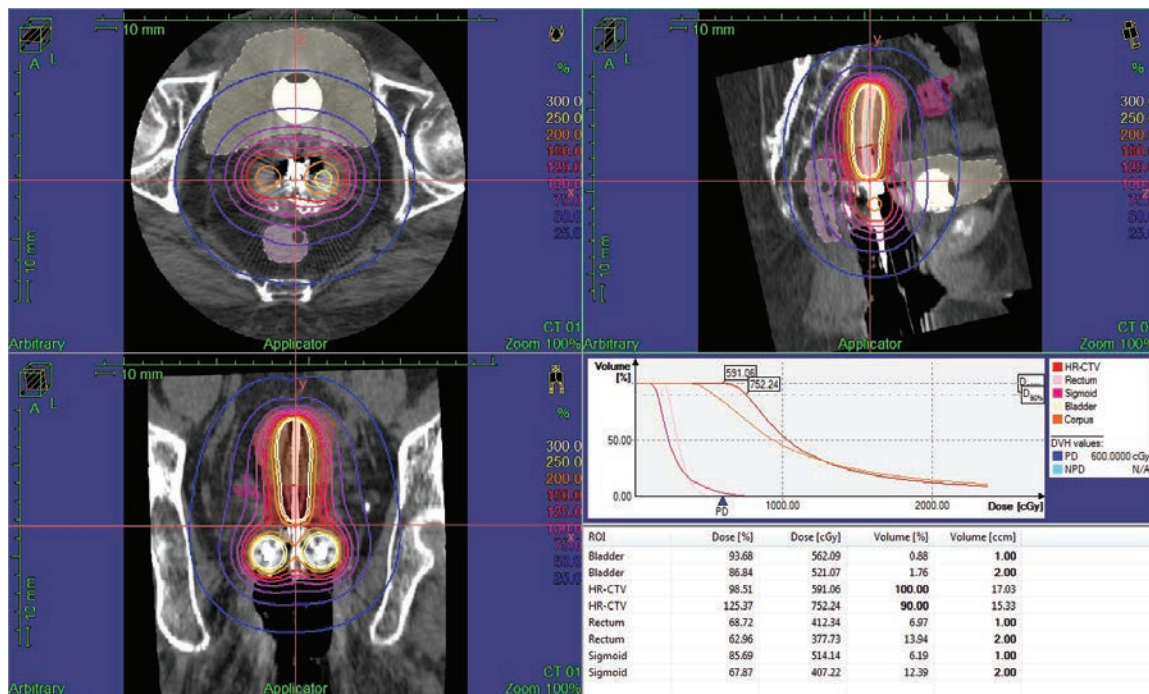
Image-guided brachytherapy (IGBT) for cervical cancer using CT images. Table (lower right) shows DVH data.
